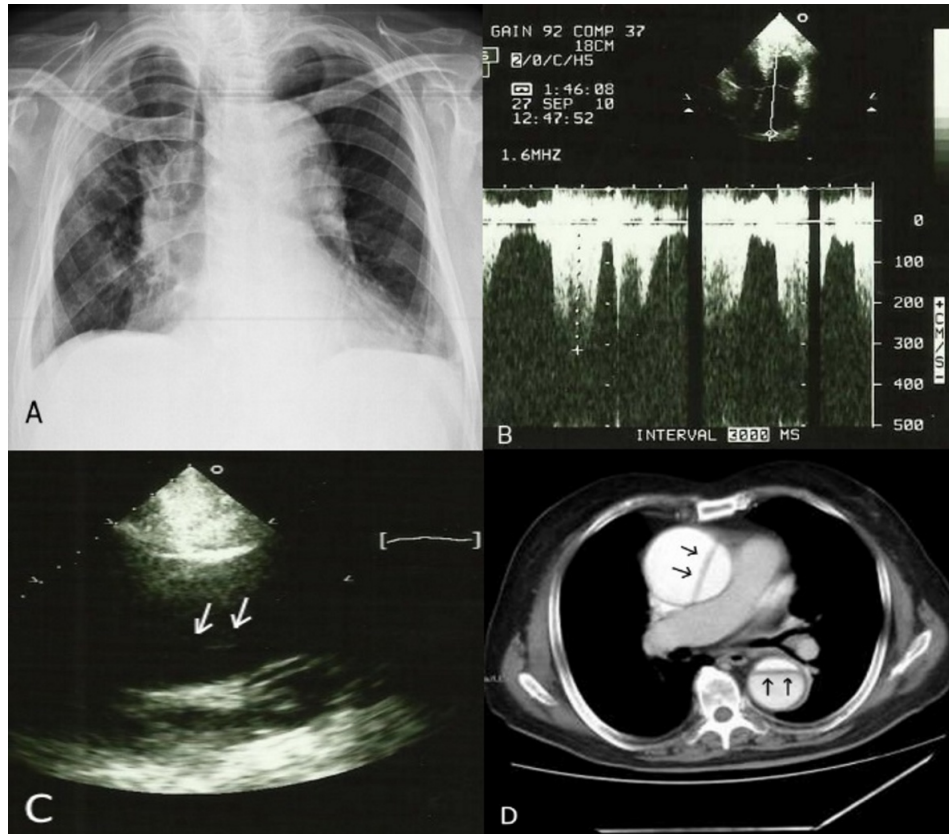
(A) Cardiomegaly and broad view in mediast were monitored on posteroanterior chest radiograph; (B) Transthoracic echocardiography revealed right heart dilatation and moderate pulmonary artery hypertension (50 mmHg); (C) 5.8 mm diameter of the ascending aorta with aneurysm view in the parasternal long-axis and dissection flap were observed in transthoracic echocardiography (*white arrows*); (D) Flap of chronic type I dissection in both ascending and descending aorta and true and false lumen images were observed in the thoracic CT (*black arrows*).
